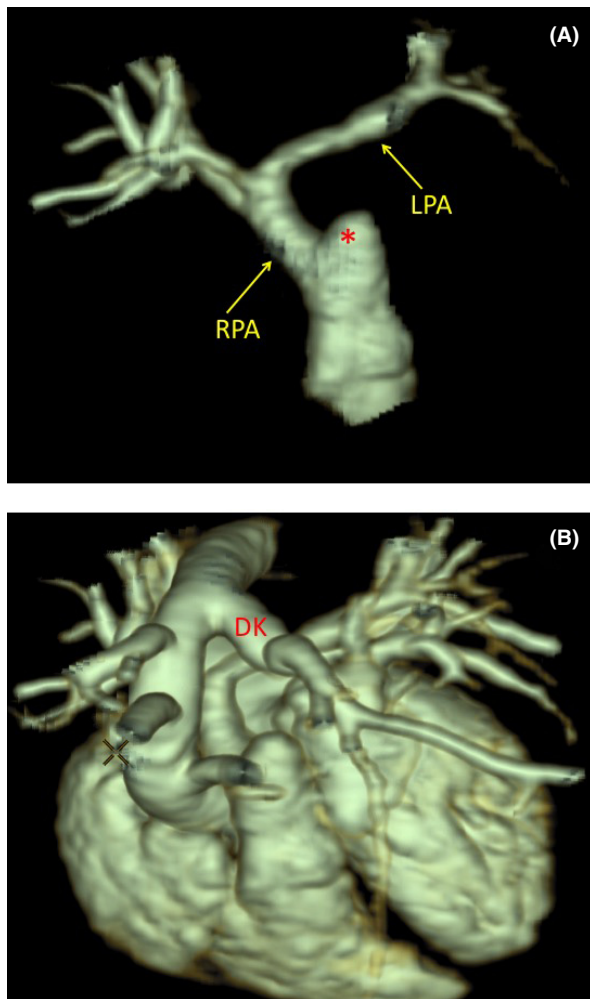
(A) Postnatal CT 3D reconstruction showing the stump of the normal origin of the LPA (*), which here arises from the right pulmonary artery (RPA). (B) Postnatal CT 3D reconstruction showing the diverticulum of Kommerell (DK) arising from the right aortic arch forming the vascular ring.
